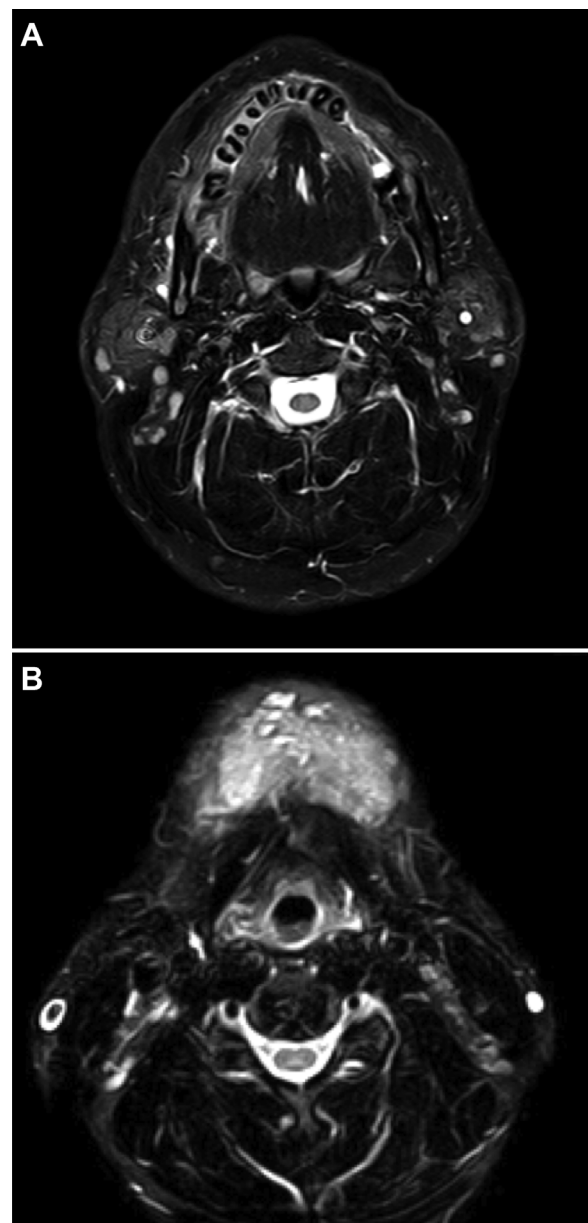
Magnetic resonance imaging (MRI). (A) Mandibular alveolar region showed multiple high signals in the lesion. (B) Submental region showed multiple high signals in the lesion; its border was indistinct under the mentum.
